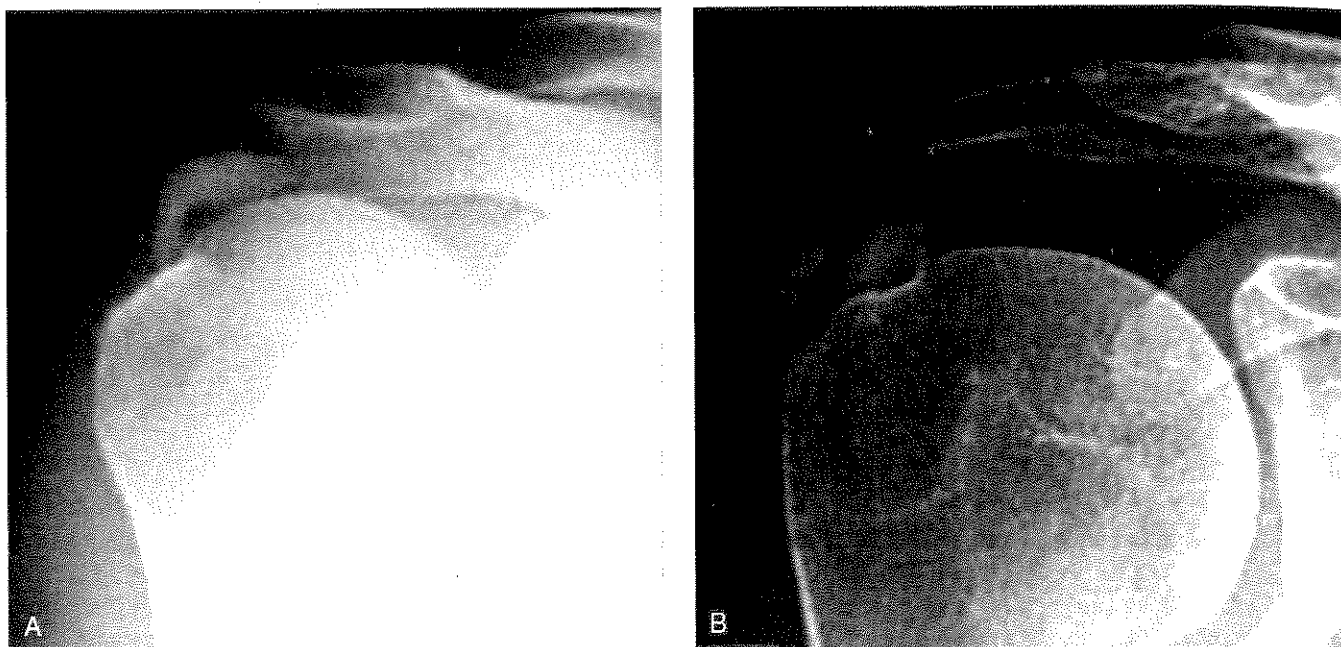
AP radiographs showing calcifications. A, Dense, rounded, and sharply delineated calcification (DePalma type II, Gärtner type III). B, Multilobar, radiodense, and sharply delineated calcification (Gärtner type II). (Reproduced with permission from Porcellini G, Paladini P, Campi F, Paganelli M: Arthroscopic treatment of calcifying tendinitis of the shoulder: Clinical and ultrasonographic follow-up findings at two to five years. *J Shoulder Elbow Surg* 2004;13:503-508.)
